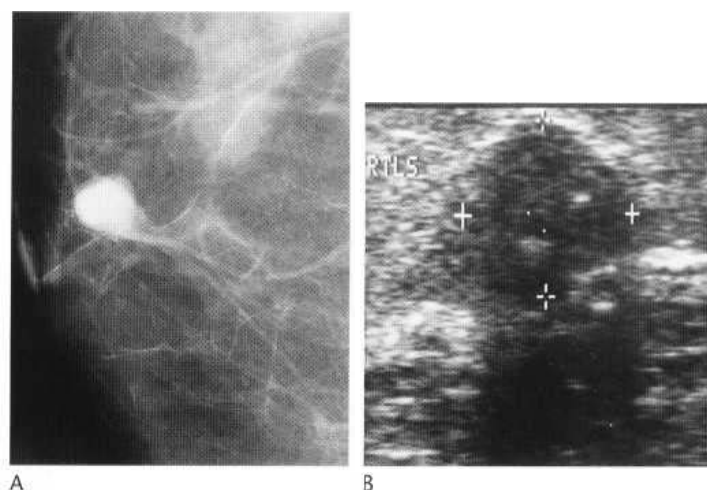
Fibroadenoma. (A) Mammogram-a circumscribed soft-tissue-density lesion. (B) Ultrasound-a circumscribed solid low reflectivity mass with posterior acoustic shadowing. A focus of calcification is seen.
